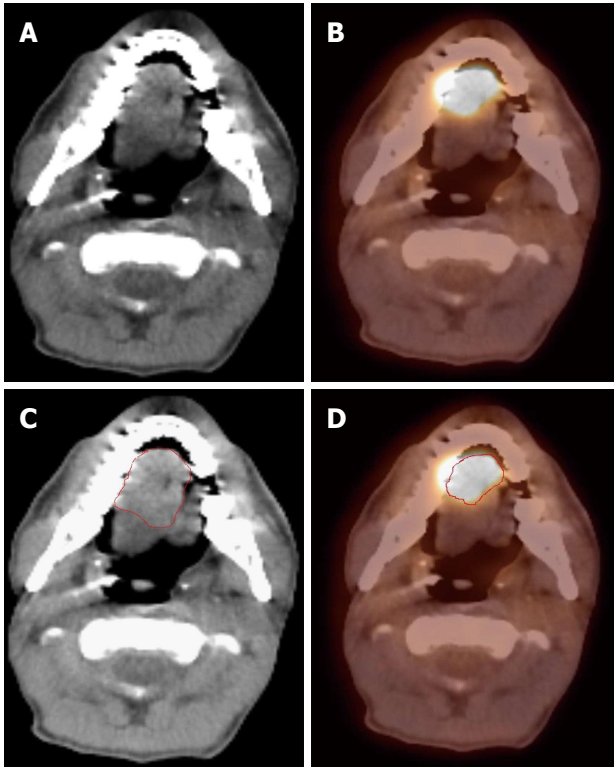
Positron emission tomography/computed tomography improves gross tumor and nodal volume delineation in a patient with oral tongue cancer. A: In the CT image, the tumor is difficult to separate from the soft tissues of the tongue; B: In the PET image, there is sharp demarcation of the primary tumor; C: The GTV is outlined in red based on CT scan; D: The GTV outlined in red based on ^{18}F FDG PET/CT is much smaller. ^{18}F FDG-PET/CT: 18 -fluorodeoxyglucose positron emission tomography/computed tomography; GTV: Gross tumor and nodal volume.
